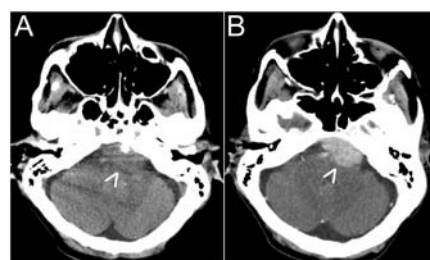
Axial section from a non-contrast head CT (A) demonstrates an isodense, extra-axial, clival-based mass centered in the left pre-pontine cistern with mass effect on the pons. Following contrast administration (B), the lesion shows avid, homogenous enhancement.
